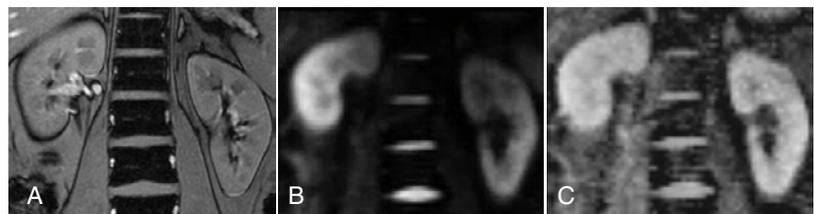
(A) Morphological MRI, (B) EPI-image for $b=0 \text{ sec/mm}^2$, (C) ADC_T from the diffusion scan of a native kidney to demonstrate dielectric effects.
